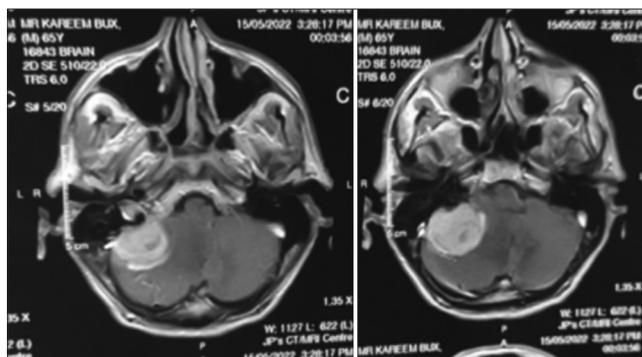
Magnetic resonance imaging brain T1-weighted postcontrast sequences.
